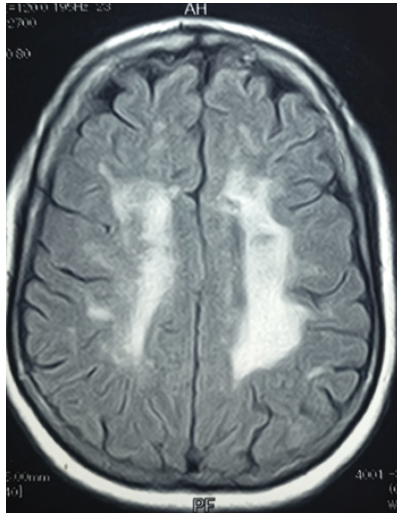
MRI axial section (T2 Flair sequence): Hypersignals in multiple confluent semi-oval centers (Fazekas score 3).
